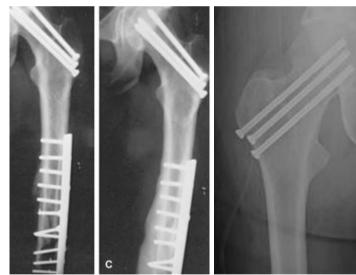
review X-ray after 4 months
